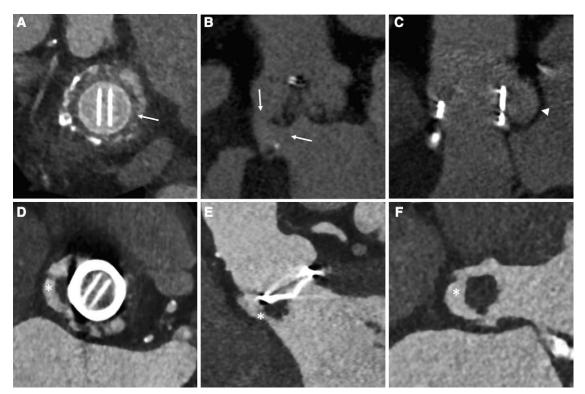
Computed tomography (CT) in periprosthetic leakage and prosthetic valve endocarditis. A, Periprosthetic leakage (arrows) in a patient with the mechanical St. Jude valve. B, Periprosthetic leakage (arrows) in a patient with the Medtronic Mosaic valve. C, Pseudoaneurysm (arrows) in a patient with the Perimount biological prosthesis. D–F, Endocarditis in a patient with a mechanical St. Jude prosthesis in aortic position. CT showed a large vegetation and provided information on mycotic aneurysm extension (D, short-axis view: valve level; E, perpendicular plane: valve level; F, short-axis view: subprosthetic level).
